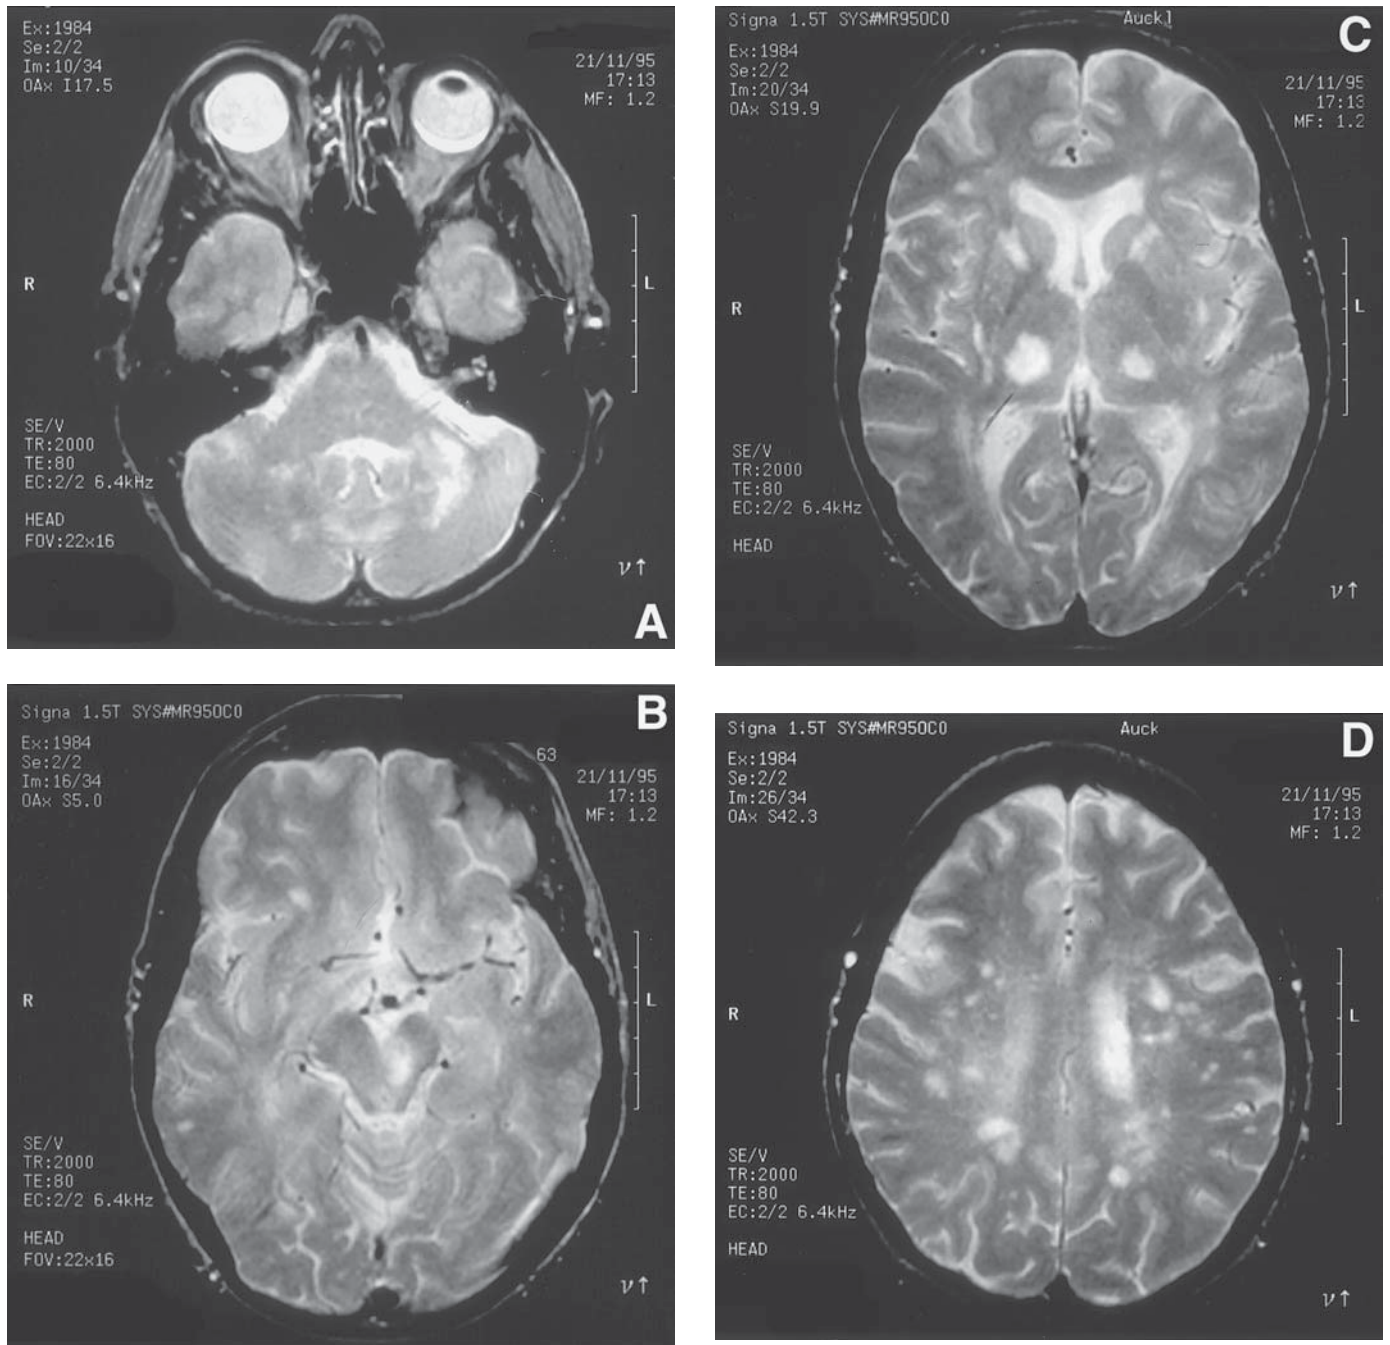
(A–D). T2-weighted MRI in a 63-yr-old woman with non-Hodgkin's lymphoma and PML shows multiple white matter lesions in the cerebellar peduncles, cerebellum, brain stem and white matter of the cerebral hemispheres. Lesions in PML occasionally involve the thalamus (C).
